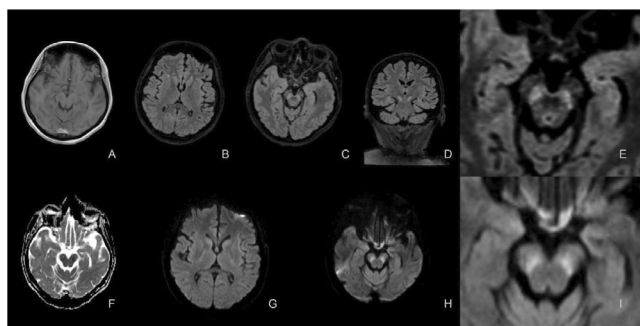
Cerebral MRI showing bilateral extensive substantia nigra lesions, with hyperintense signal in T2/FLAIR and restriction of diffusion on DWI.
